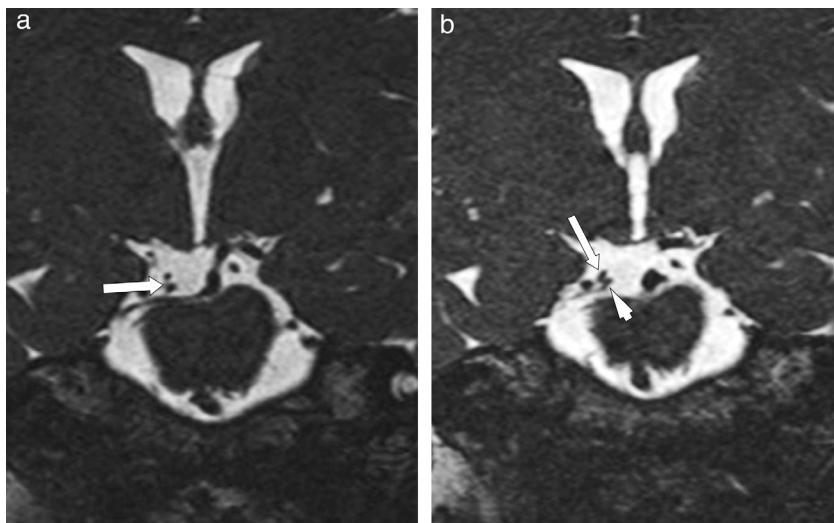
Brain MRI. a) Zoomed view of coronal slice: we observe oculomotor nerve (OMN) in contact with the right posterior cerebral artery (PCA). b) Zoomed coronal slice: OMN (arrowhead), PCA (arrow).
